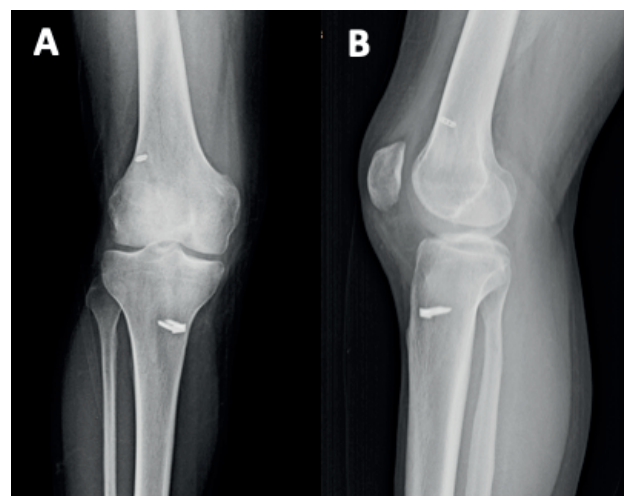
ACL reconstruction with transportal anatomical technique. (Postoperative anteroposterior (A) and lateral (B) X-Ray view)
